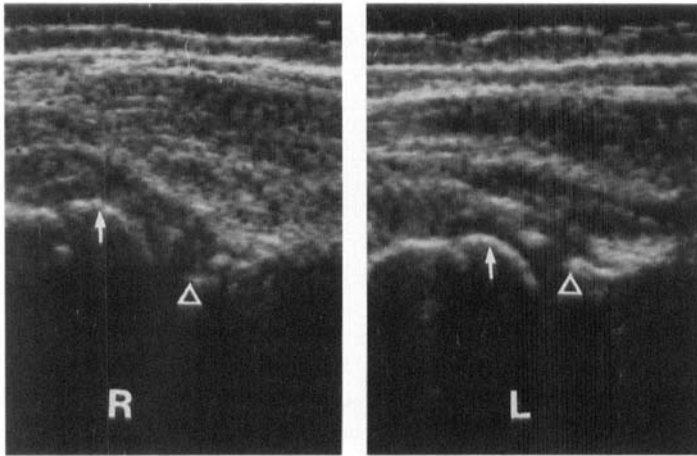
Longitudinal lateral ultrasonograms (labels as in Figure 1) of both hips in a 6-year-old girl (not included in the present material) during follow-up of previously treated hip dislocation. The femoral head is laterally displaced in the right hip (R), indicating slight subluxation, whereas the left hip (L) is normal. Radiography confirmed the ultrasound findings.
